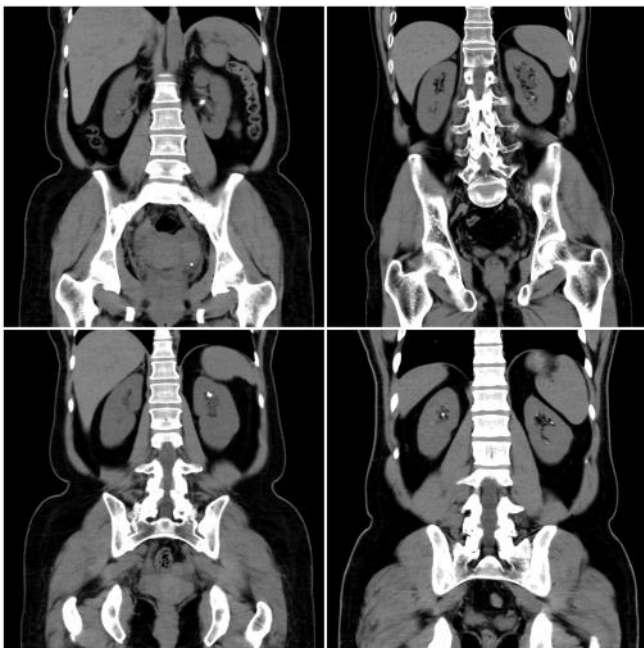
CT scans displaying kidneys with the presence of kidney stones
